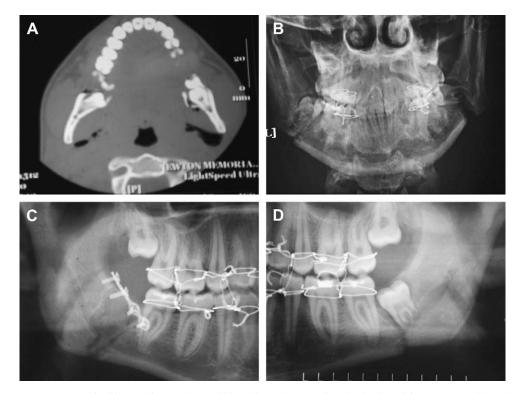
(A) CT scan of a bilateral fractured mandible with teeth #17 and 32 in the line of fracture. (B) After a closed reduction, it was noted that tooth #32 displaced the fracture segments. (C) Tooth #32 was extracted and an intraoral open reduction was performed. (D) The tooth #17 was left in the line of fracture so as not to displace the segments with extraction.
